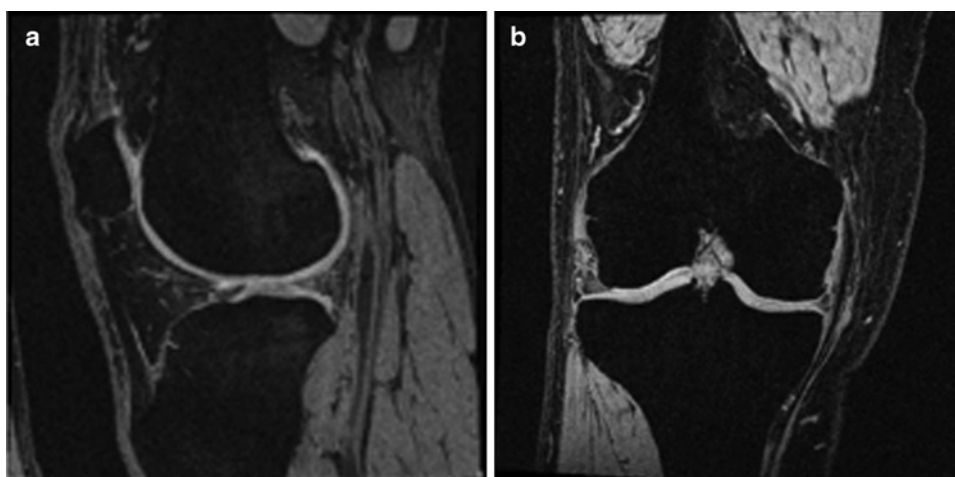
MR images of the knee joint at 3.0 T for cartilage morphological quantification in the OAI. (a) DESS-WE in the sagittal orientation with in-plane spatial resolution of $0.365 \text{ mm} \times 0.365 \text{ mm}$ and slice thickness of 0.7 mm. (b) FLASH-WE in the coronal orientation with in-plane spatial resolution of $0.312 \text{ mm} \times 0.312 \text{ mm}$ and slice thickness of 1.5 mm
